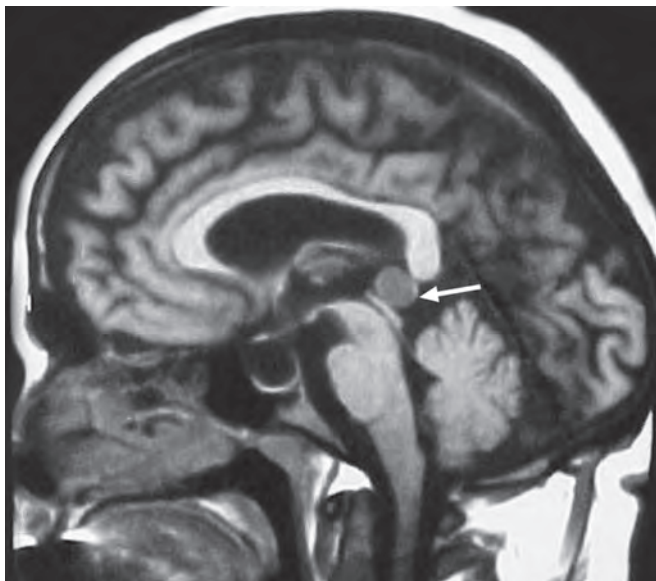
MRI of a patient having a pineal tumour (white arrow) and empty sella
